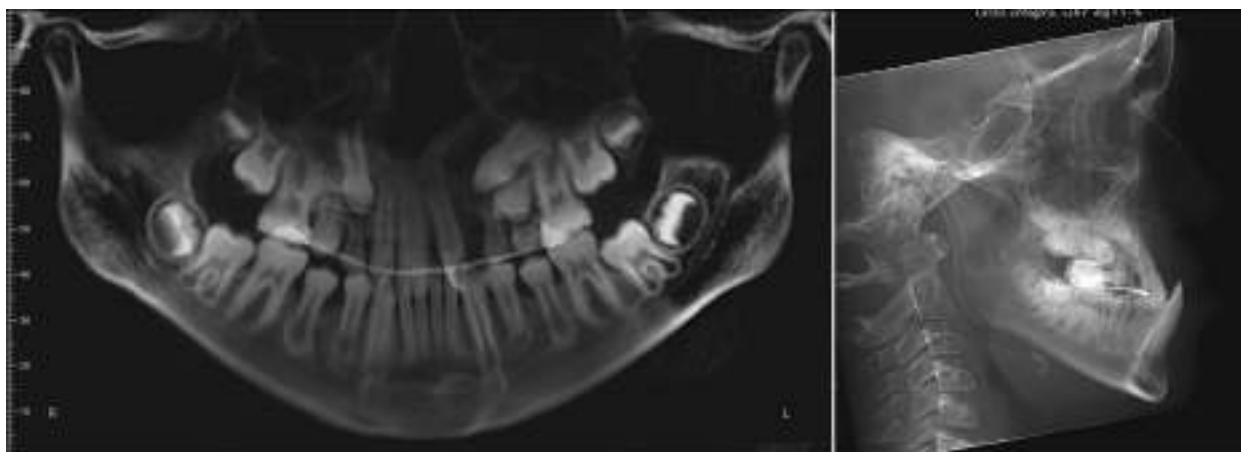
Panoramic and cephalometric radiographs. Observe the Class III facial profile with sagittal maxillary deficiency, with a 5.8-mm negative overjet. The patient was in the mixed dentition with agenesis of the maxillary second premolars and maxillary left lateral incisors.
